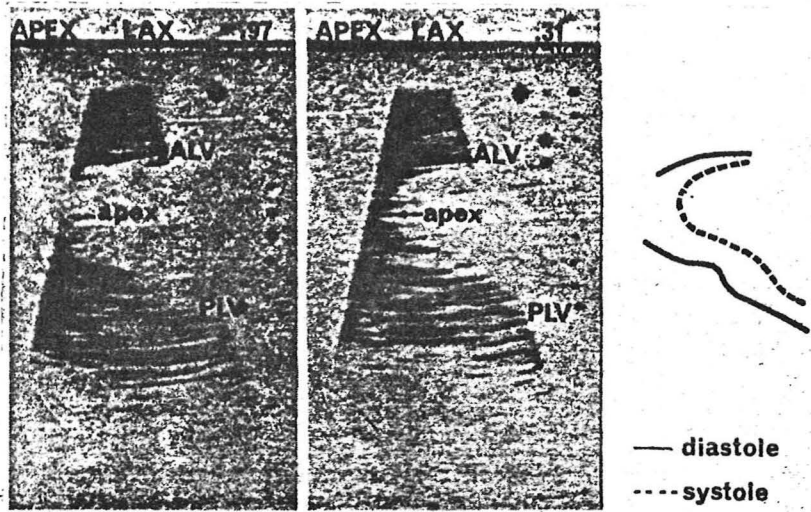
Two-dimensional echocardiogram of the left ventricular apex of a normal subject. ALV=anterior left ventricular wall; PLV=posterior left ventricular wall; LAX=long axis section (45).
